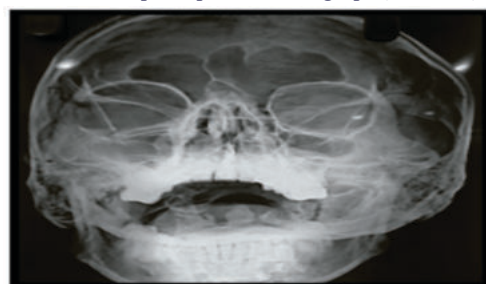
One-month post-operative radiograph (PNS view)
